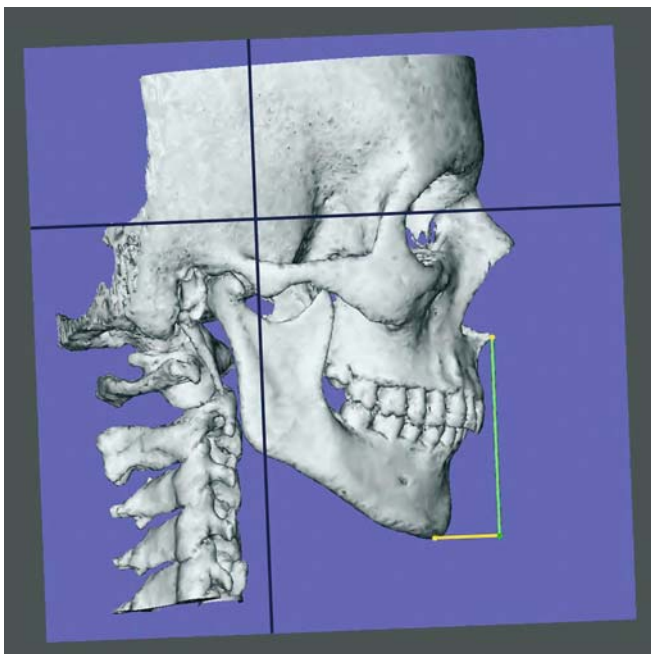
Anterior lower facial height, ANS-Me (3-D CT, hard tissues, patient K.C.)
